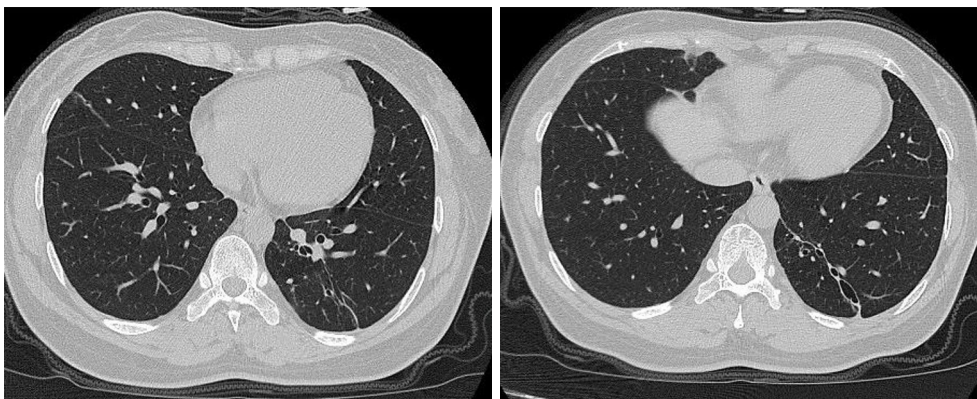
Case 3, a 49 years old female, chest CT shows bronchiectasis with linear shadow around at right middle lobe and left lower lobe of the lung. No viral pneumonia.
